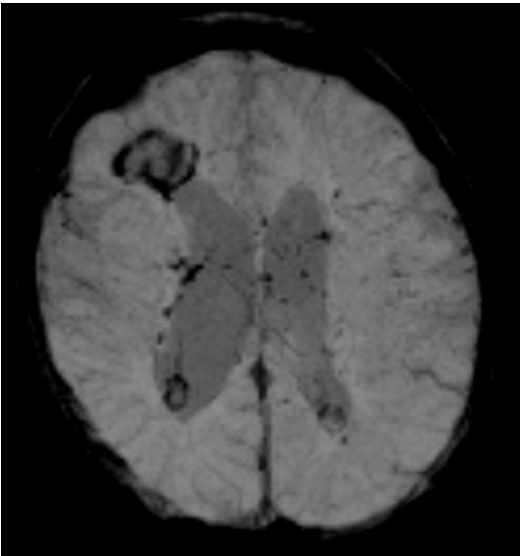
MRI, Pat. 2, at five months of age.
